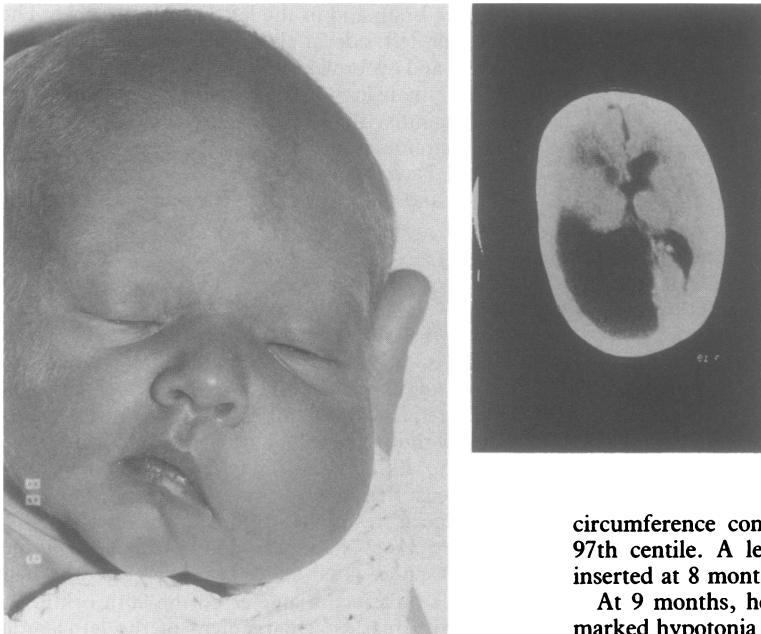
Case 3 newborn and CT scan at 3 months.
